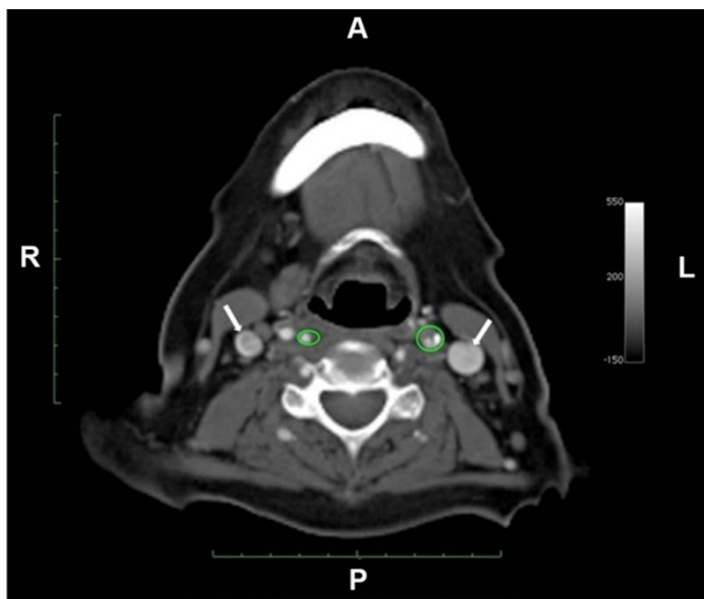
Contrast enhanced CT; diagnostic CTA performed with intravenous injection of contrast with bolus tracking of the ascending aorta and a cutoff value of 80 HU. In green are ROIs encircling the left and right internal carotid artery, white arrows point to the jugular veins. CT = computed tomography, CTA = CT angiography, HU = Hounsfield units, ROI = region of interest.
